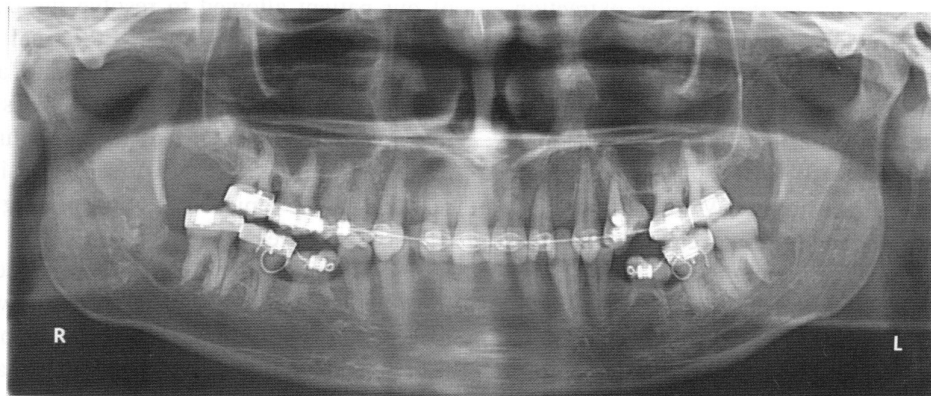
Radiographic control 20 days after the lower third molar extractions. On the left side we reported a dry alveolar post-extractive socket.
